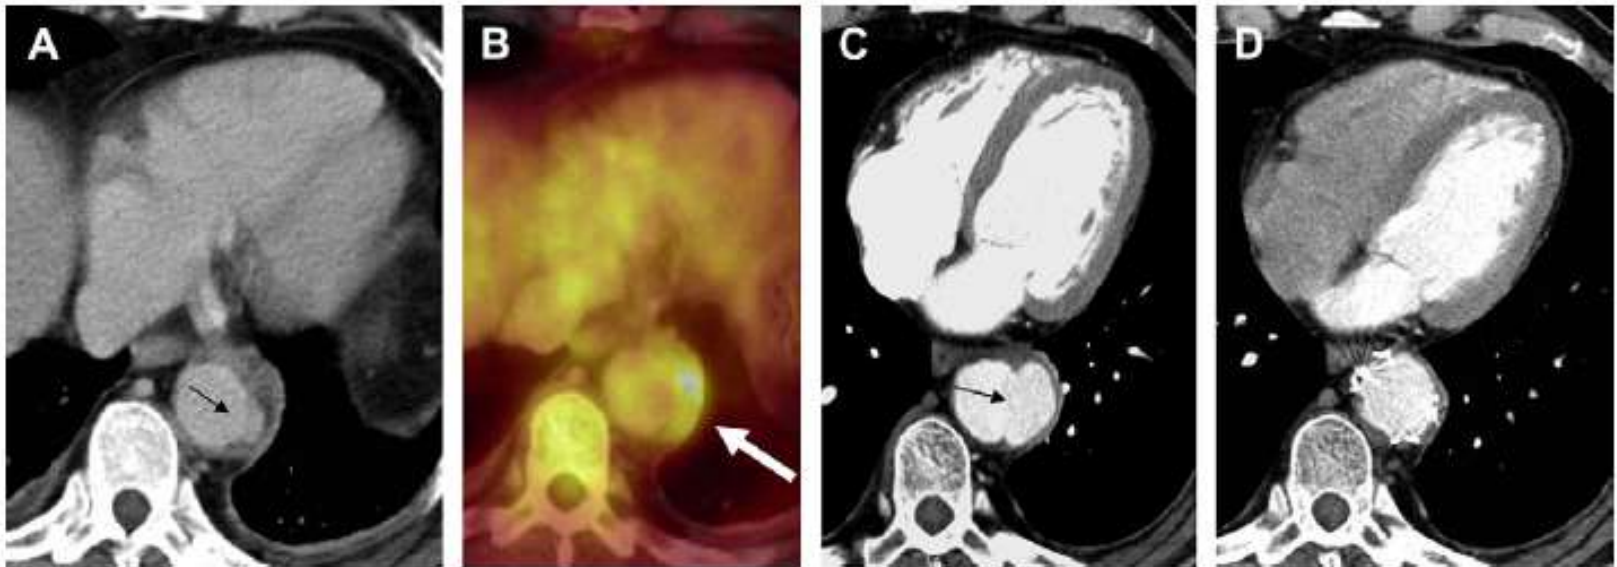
A. Penetrating aortic ulcer (arrow) in an acute aortic syndrome patient. B. Fused PET-CT image showing increased glucose metabolism within the PAU (arrow). C. Progression towards pseudoaneurysm formation (arrow) under medical treatment. D. Result after TEVAR with complete resolution of the ulcer.
